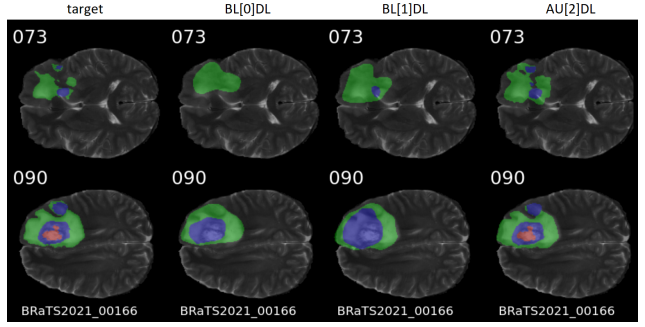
Segmentation predictions overlaid on T2 MRI.
